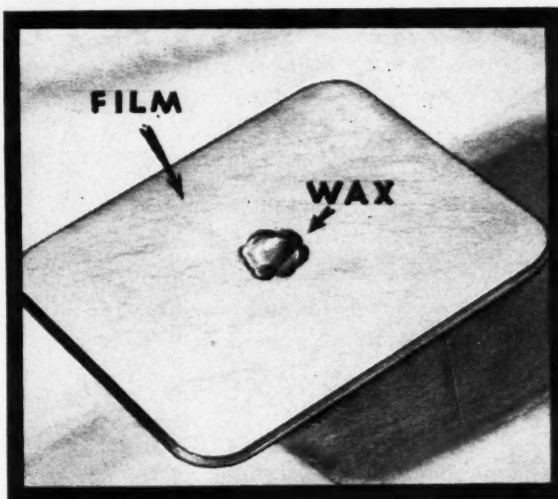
A drop or two of pink wax on the center of a film provides a guide for deft fingers or clumsy thumbs in centering the x-ray film.
